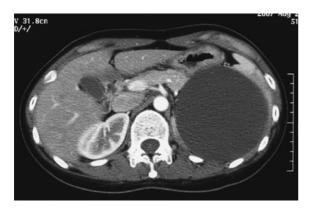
Abdominal CT showing a large cystic tumor with homogenous liquid contents in the upper pole of the spleen, compressing the gastric body of the stomach.
